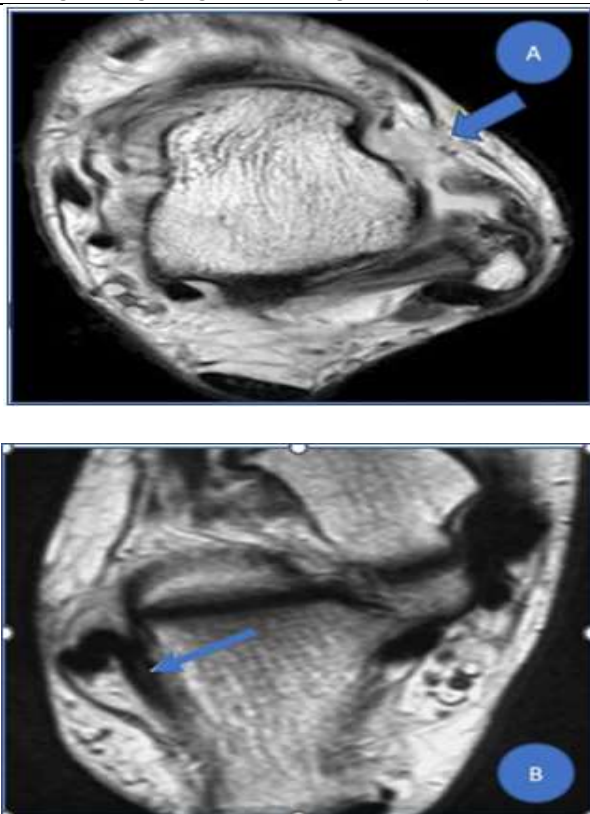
A – Grade 3 Injury of ATFL in patients with the age of 38 years, B – The calcaneofibular ligament (arrow) is also apparent as it courses deep to the peroneal tendons on this T2-weighted axial view.
